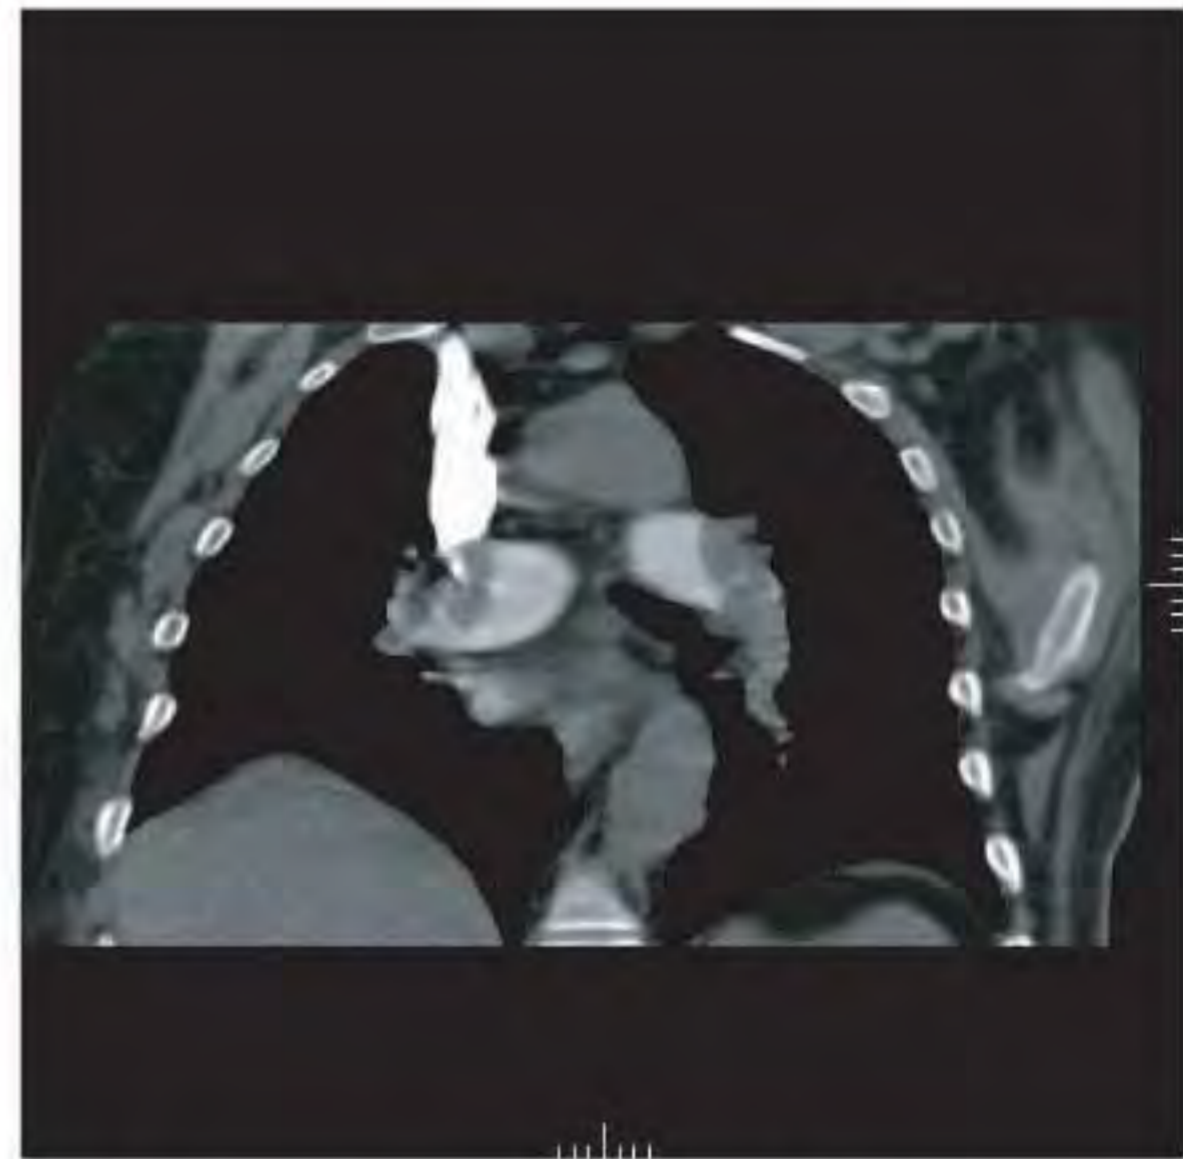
Coronal plane reconstruction of CT angiogram of chest, showing embolus (black arrows) in both right and left main pulmonary artery branches.
